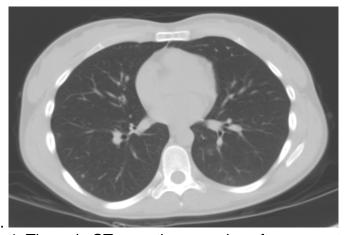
Thoracic CT scan three weeks after presentation.
